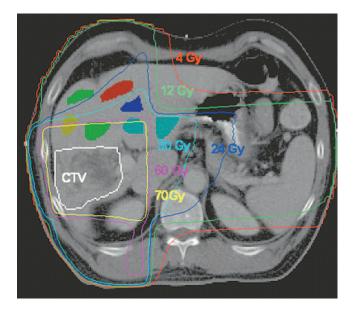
Isodose curves and the clinical tumor volume (CTV) overlaid on a CT liver slice. Volumes of interest (in colors) were drawn in the regions beyond CTV and distributed over high to low doses.
